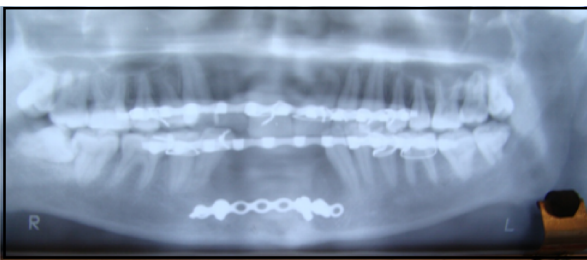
Post Operative Radiograph Showing Erich Arch Bar & Single Plate At Lower Border of Mandible
